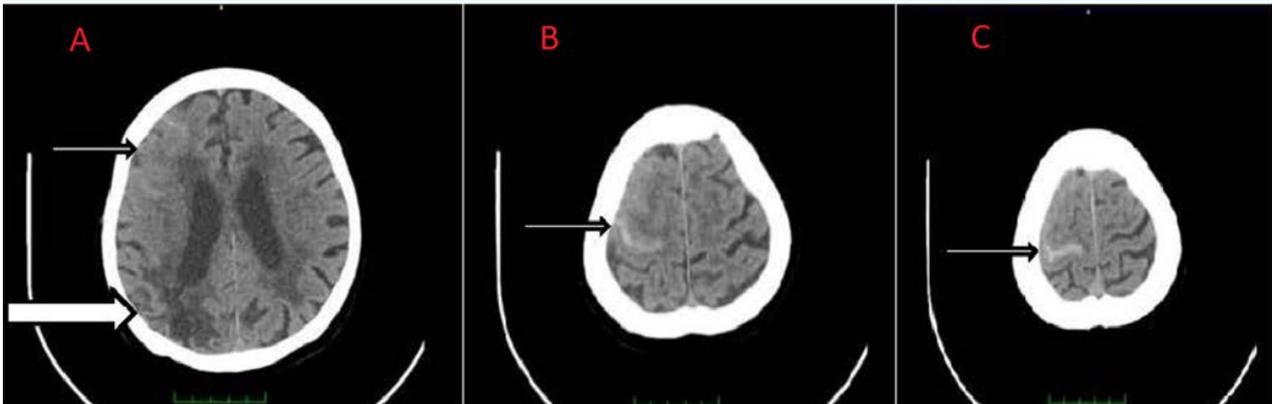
A 89-year-old female patient admitted to the emergency room for focal motor seizure. A. Encephalomalastic area (thick arrow) due to hemorrhage on unenhanced brain CT, B and C convex subarachnoid hemorrhage (thin arrows).
